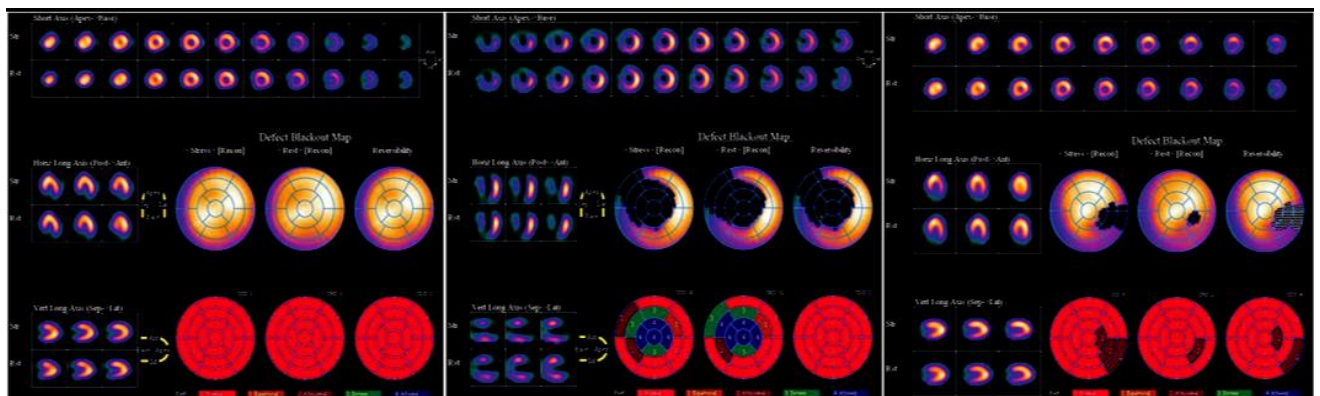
Representative post-stress and rest GS MPI images in post CR patients. There is (a) normal myocardial perfusion in a 67 years old male; (b) extensive fixed perfusion defect in LAD territory in a 50 years old male and (c) reversible perfusion defect in LCX territory in a 68 years old male. LV slices are displayed in three standard axes; perfusion map in 17 LV segments with perfusion scores displayed using 4DMSPECT
